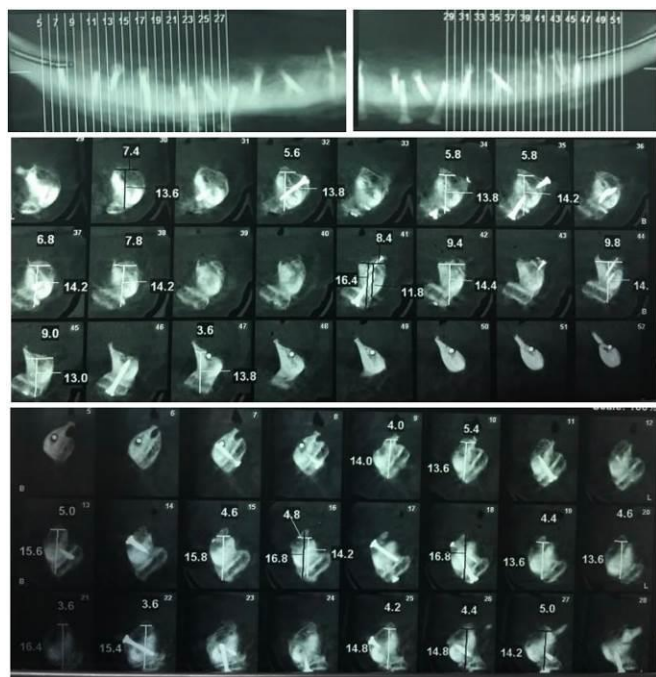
The cone-beam computed tomography of reconstructed mandibular ridge six months post-operatively
